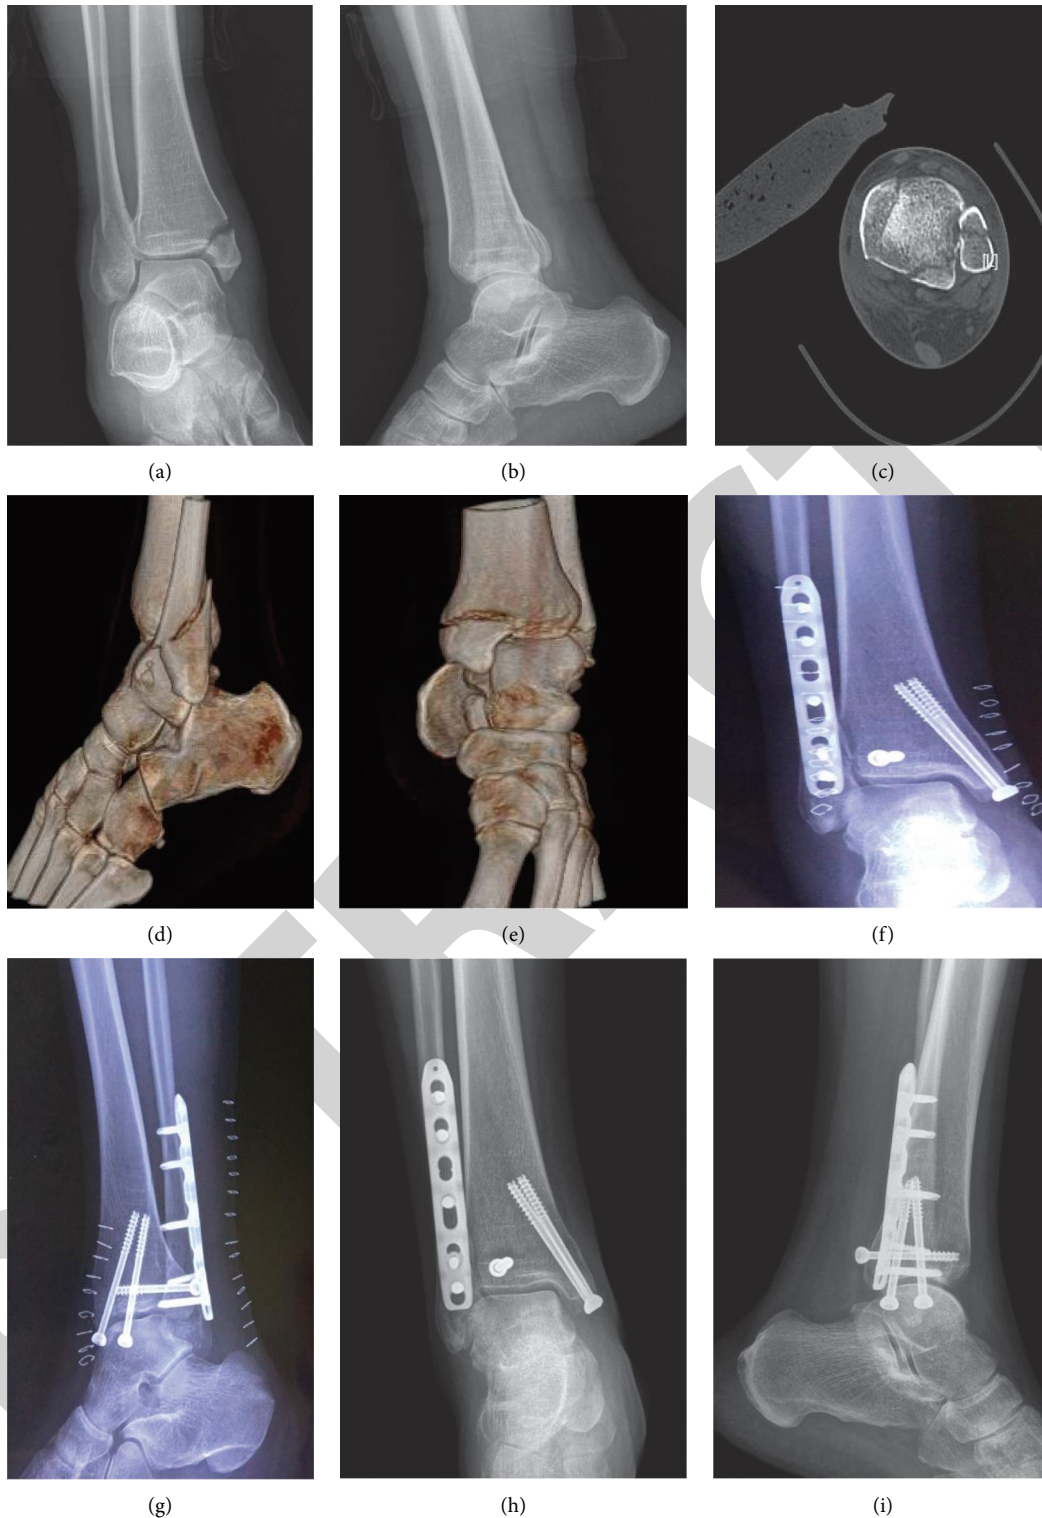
(a, b) 45-year-old female patients with right ankle fracture caused by trauma. (c–h) CT scan shows that the fracture involves medial, lateral, and posterior malleolus. The fracture belongs to the supination-external rotation-type (Grade IV). (c–f) The prone position and posterolateral approach were used. The fibula was fixed by a plate, the posterior malleolus was fixed by a lag screw, and the medial malleolus was fixed by two hollow screws. (h, i) One year after surgery, the X radiographs show that the fractures were healed well and the ankle function recovered excellently.
